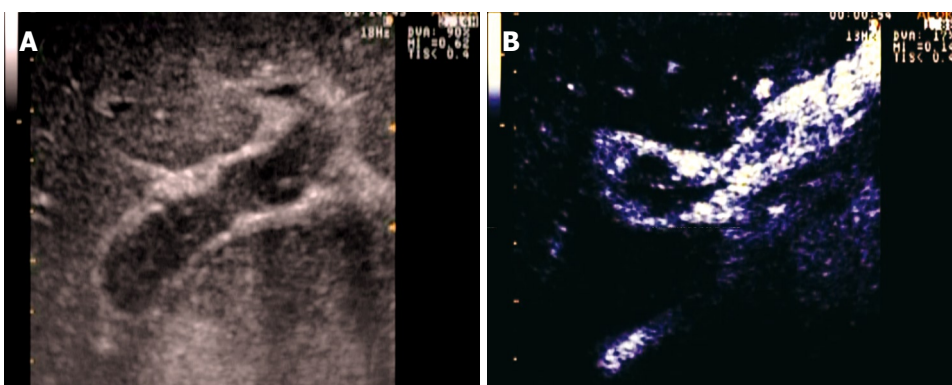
Malignant mosaic thrombus. A: Sonography scan reveals isoechoic area within portal lumen representing thrombus; B: Contrast enhanced sonography scan during late arterial phase reveals thrombus as predominantly enhancing area, indicative of arterial neovascularization (malignant thrombosis) with some non-enhancing areas of the thrombus (mosaic pattern).
